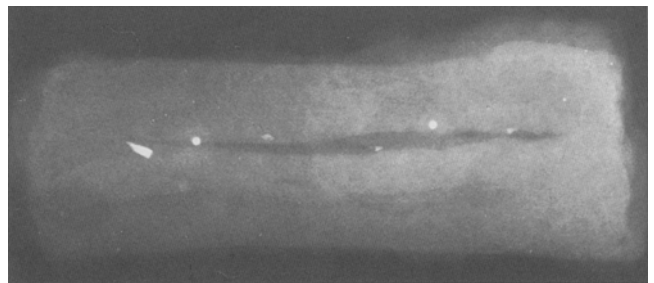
Sliver of safety glass (low energy X-ray imaging)
